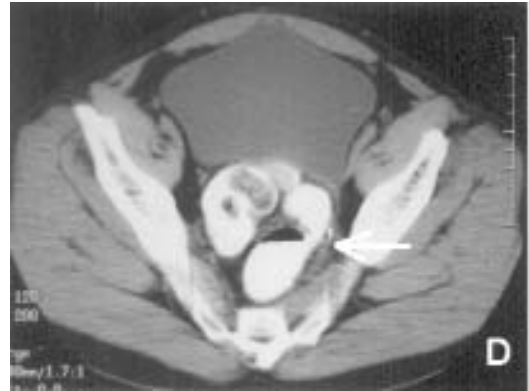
CT scan of lower abdomen and pelvis revealing the disappearance of the cystic lesion following three courses of oral administration of albendazole.
